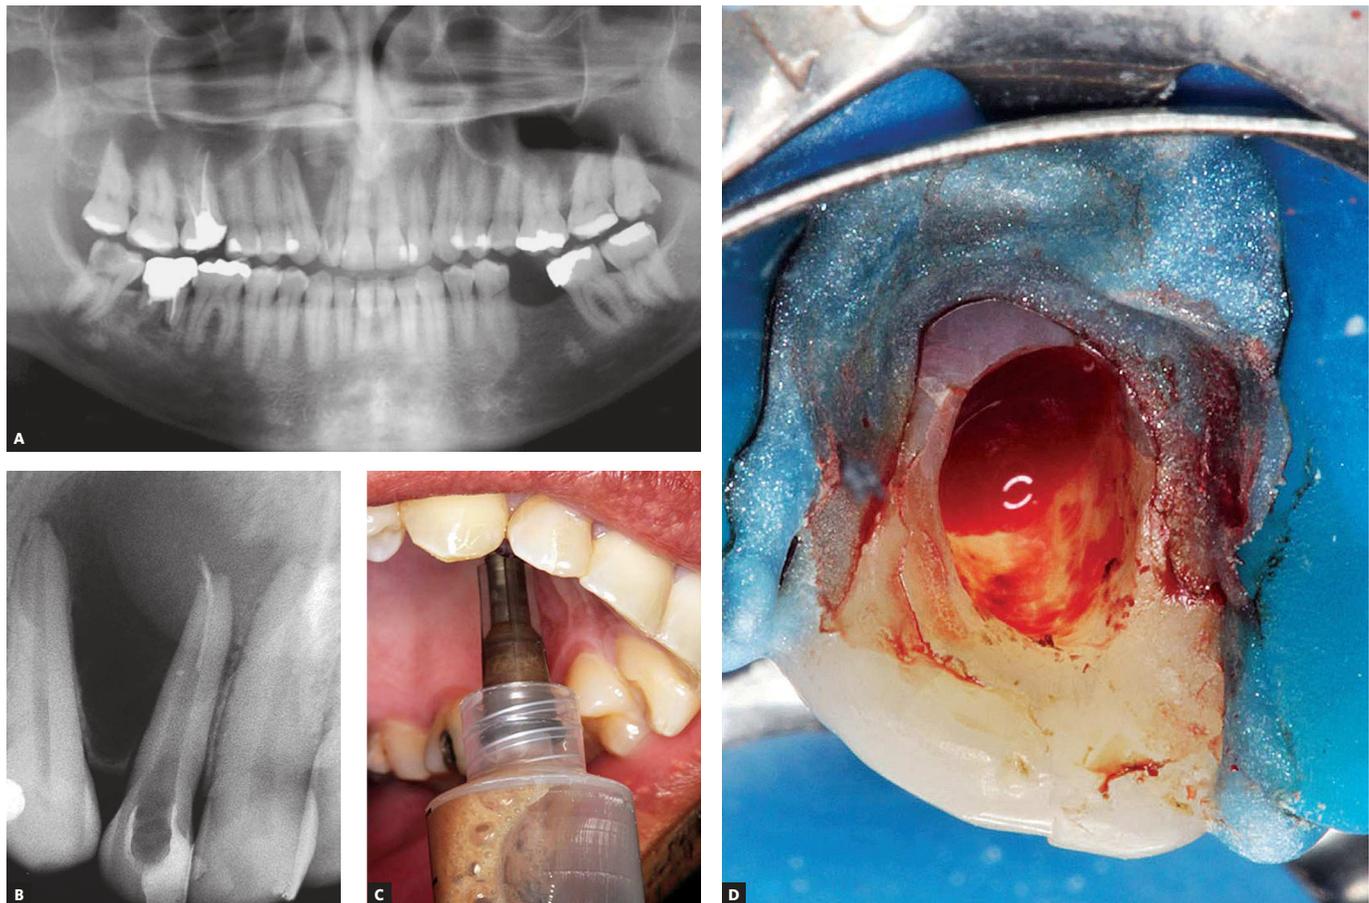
A) Large periapical lesion in maxillary right lateral incisor region observed in panoramic radiograph. B) Open apex and gutta-percha point beyond the root apex. C) Local aspiration using Gauge 25 hypodermic needle. D) Continuous exudate drainage through the root canal.
